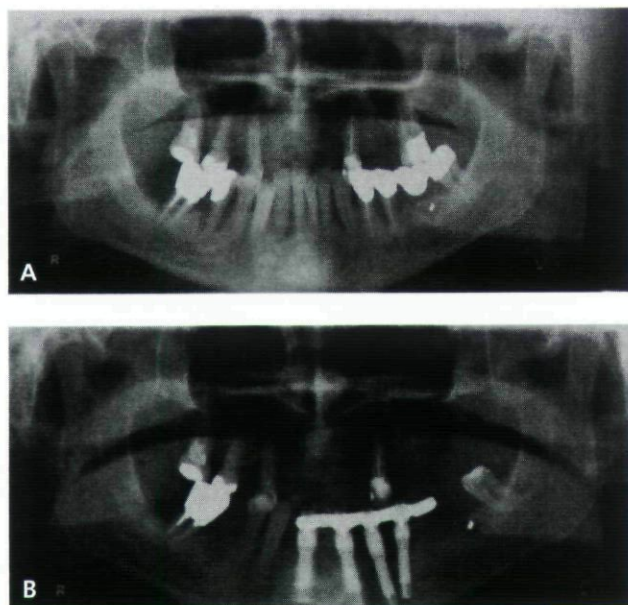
A, Pretreatment panoramic radiograph from a 60-year-old male patient showing advanced periodontal lesions involving most of the remaining mandibular teeth. Teeth 43 and 44 were judged to be recoverable and were therefore not extracted. Two remaining molars were also left, according to the wish of the patient. B, Panoramic radiograph 10 months post-surgery. C, Periapical radiographs 24 months postsurgery showing good bone healing around the four interforaminal implants.
